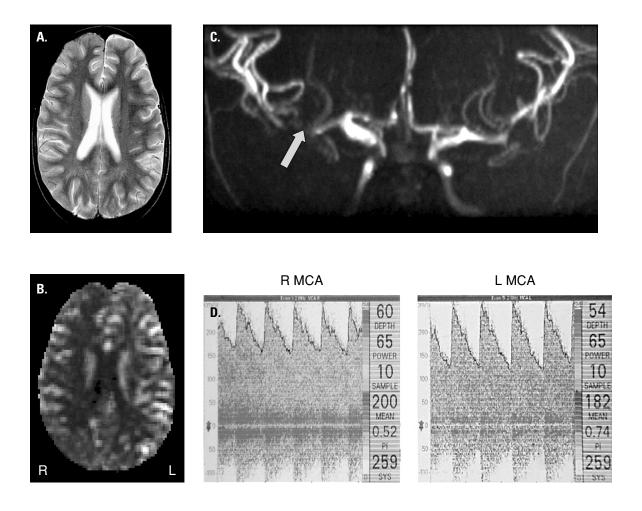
Images from a child who had recently presented with a chest crisis. (A) normal T2-weighted magnetic resonance imaging (MRI), (B) perfusion MRI showing reduced perfusion posteriorly on the left and throughout the right hemisphere, (C) bilateral turbulence on MR angiography, and (D) transcranial Doppler showing conditional velocities on the left and abnormal velocities on the right.
